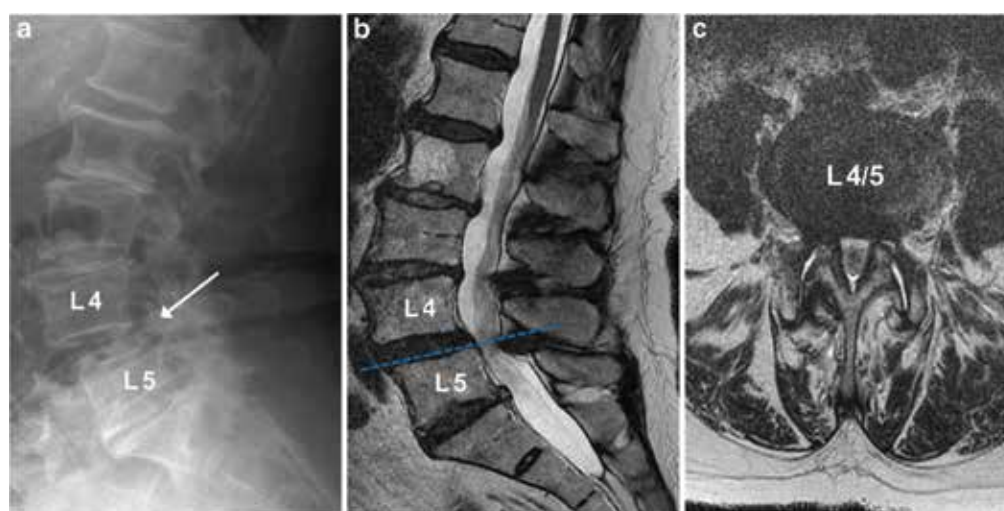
Example of a 58-year-old male patient with lower back pain and abnormal sensations in both lower extremities and buttocks, suggestive of lumbar spinal stenosis. The anterolisthesis visible at L4/5 on a the upright radiograph is markedly greater (arrow) compared with b the supine acquired sagittal T2w MR image. The extent of anterolisthesis measured on the radiograph (a) correlates with the grade of stenosis according to Schizas *et al.* [14] as assessed on c the axial T2w MR image. In c, no rootlets or cerebrospinal fluid signal are distinguishable within the dural sac at level L4/5, but there is still epidural fat present, which is equivalent to a severe grade C stenosis. Blue dashed line in b indicates the axial level shown in c.
